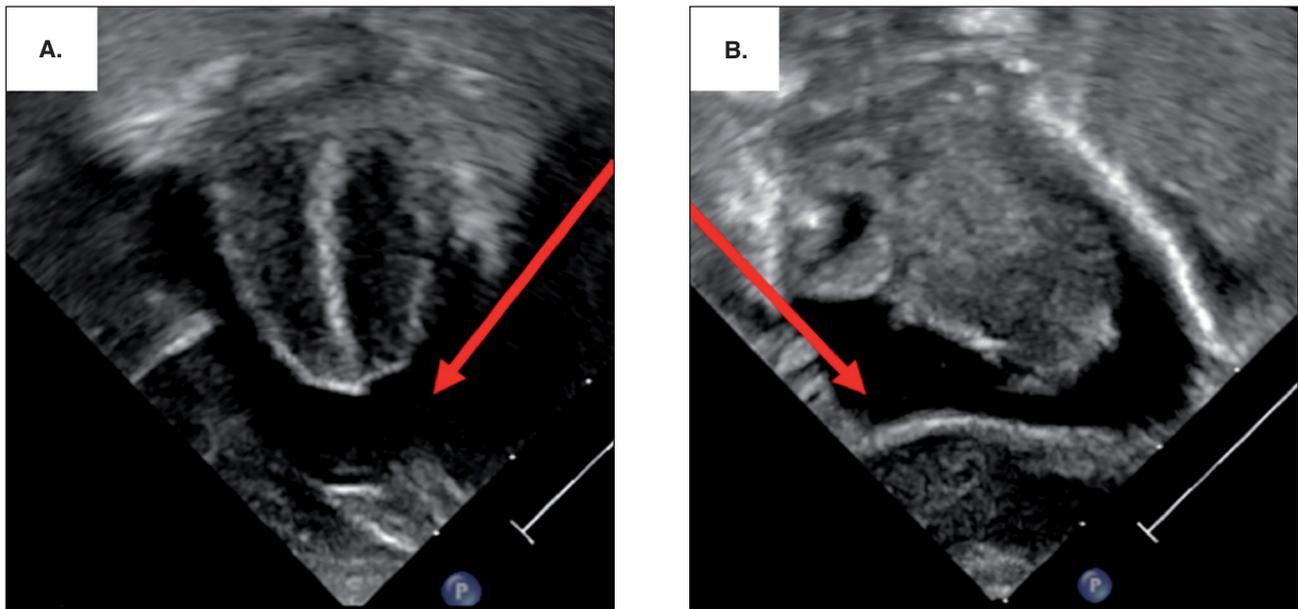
Apical 4 chamber view (A) and subcostal long axis (B) demonstrating pericardial effusion on echocardiogram (indicated by red arrows).
